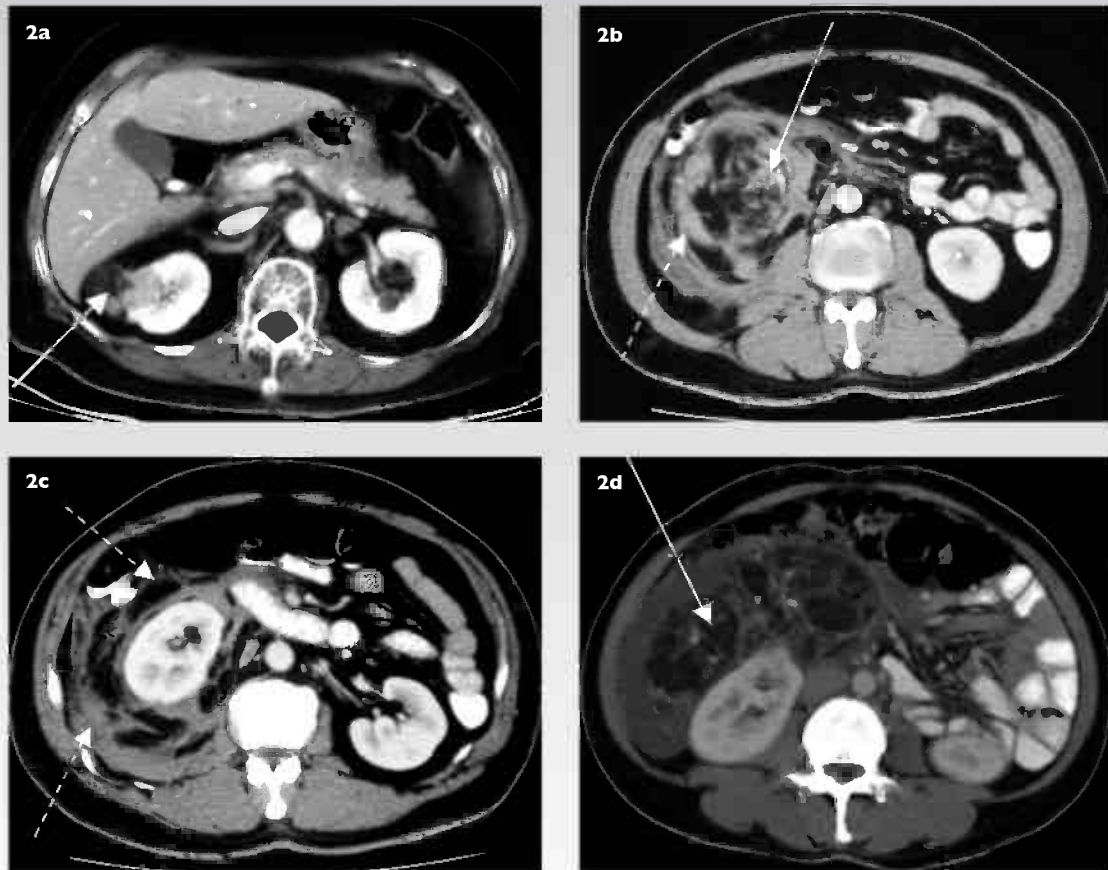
Axial CT images show (a) non-complicated renal angiomyolipoma (arrow); (b & c) renal angiomyolipoma (arrow) in the lower pole of the right kidney, complicated by perinephric haemorrhage (dashed arrows); and (d) large renal angiomyolipoma with adipose tissue component (arrow).
